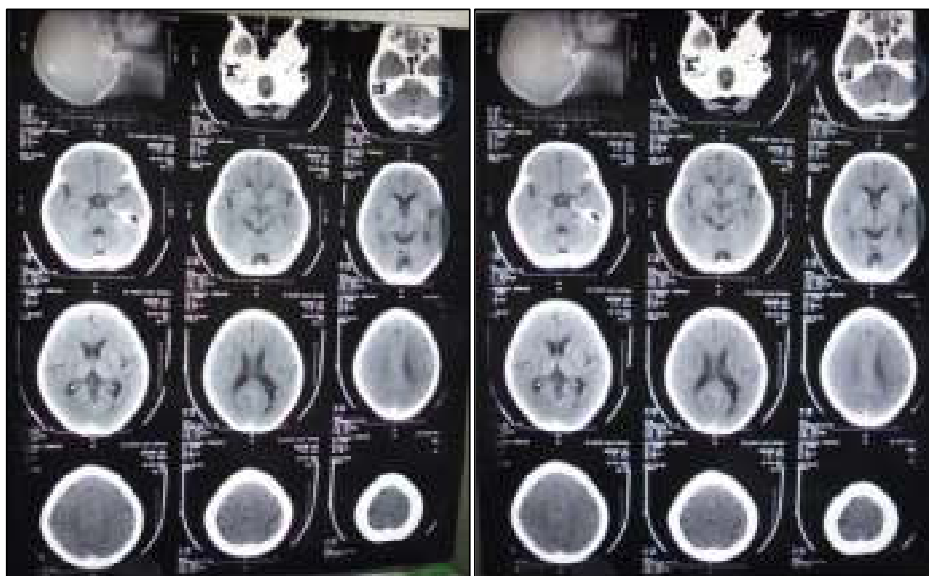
Head CT scan showed a chronic lacunar infarction at right corona radiata and mega cisterna magna occipital
